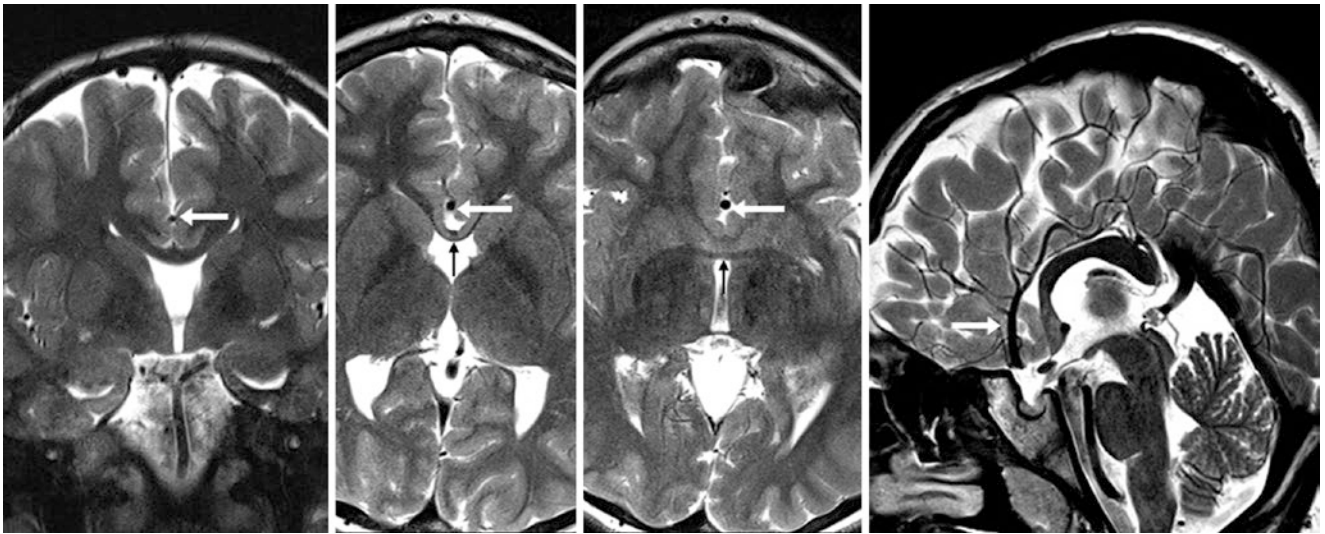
Companion case of septopreoptic holoprosencephaly: 10-year-old with an azygous ACA (arrows) in the interhemispheric fissure on coronal (left), axial (middle two images), and sagittal (right) T2WI MRI. Note a partial lack of a falx anteriorly, with interdigitating
